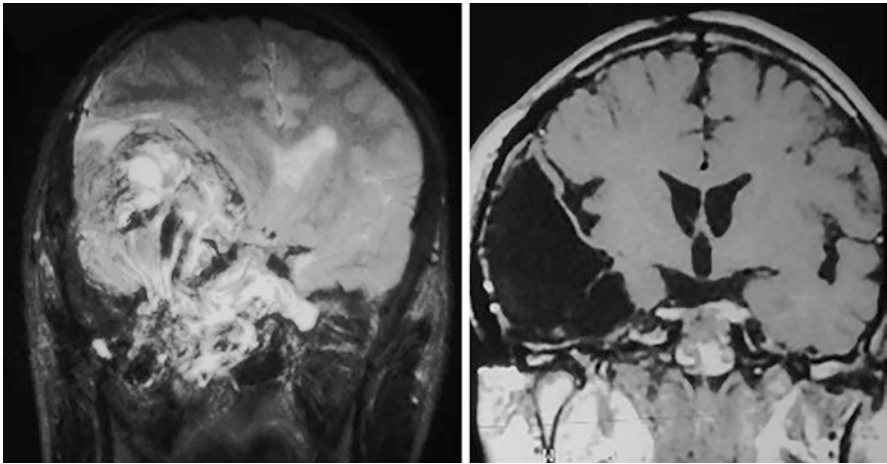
Case No 2. Simple MRI T2 weighted in coronal section that shows a huge highly vascularized tumor on the right middle fossa with invasion to the ITF and PPS (left). Tumor was completely removed “en bloc” with a ZTMA (right)
